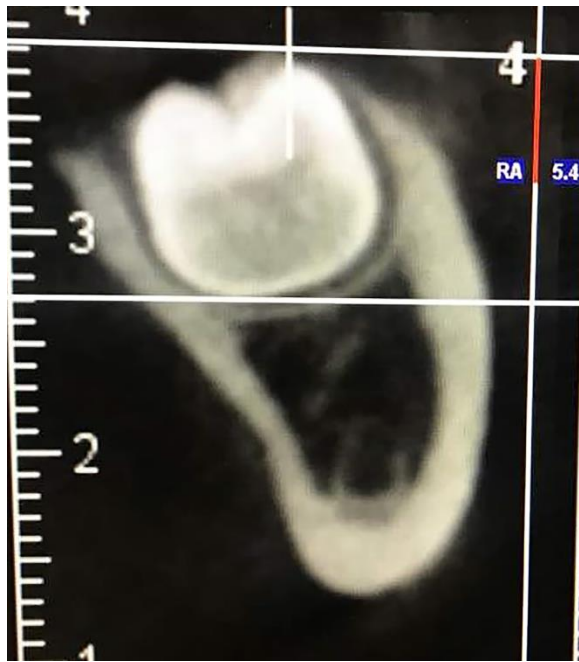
Anterior CBCT section of impacted third molar. The two white lines indicate the distance between the superior and inferior points and the distance between the two lines was measured to be 10.8 mm. This distance was divided by 2 and the obtained value was 5.4 mm (red line), referred to as RA.
